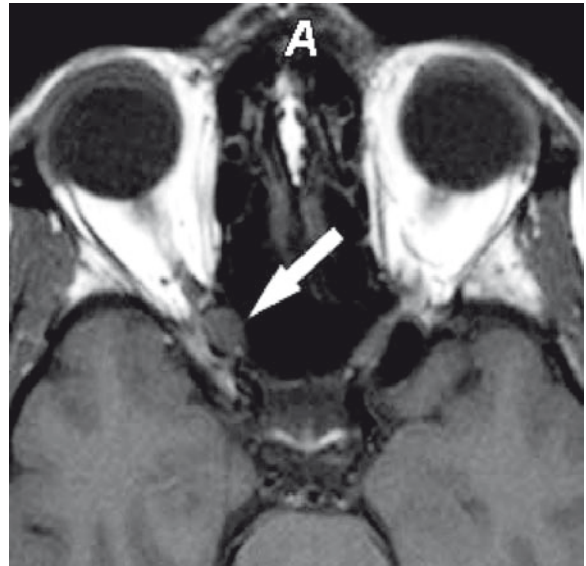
Corresponding sagittal T1-weighted (T1w), contrast enhanced, fat-suppressed view with signal enhancement of the tumor (*white arrow*)
